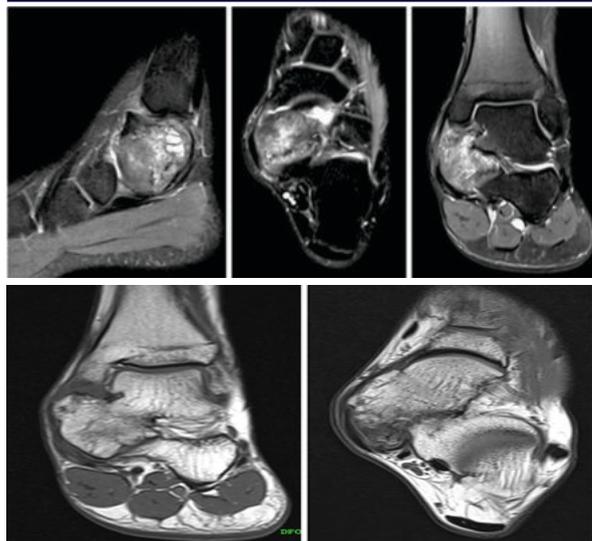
A comprehensive depiction of the tumor with MRI conducted in Sagittal, Axial and Coronal planes.
